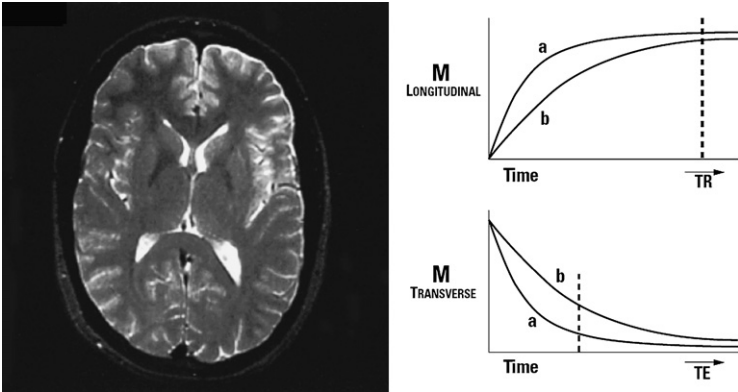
T2-weighted image acquired using long TR and adequate TE. (Courtesy of GE Healthcare, São Paulo, Brazil.)
